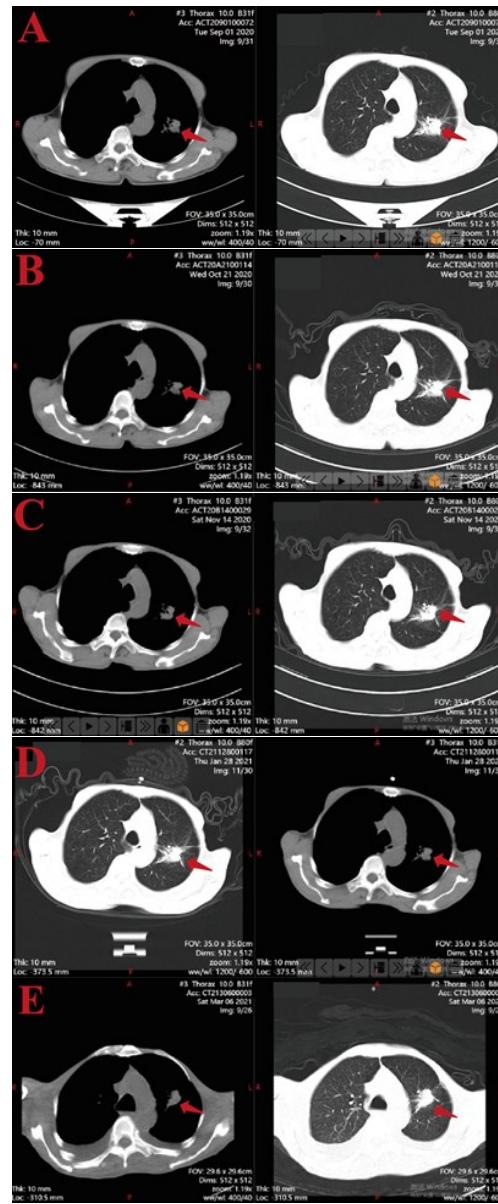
CT images of the patient's lungs during treatment (A: CT images of the patient's lungs at 2020_09_01; B: CT images of the patient's lungs at 2020_10_21; C: CT images of the patient's lungs at 2020_11_14; D: CT images of the patient's lungs at 2021_01_28; E: CT images of the patient's lungs at 2021_03_06).
